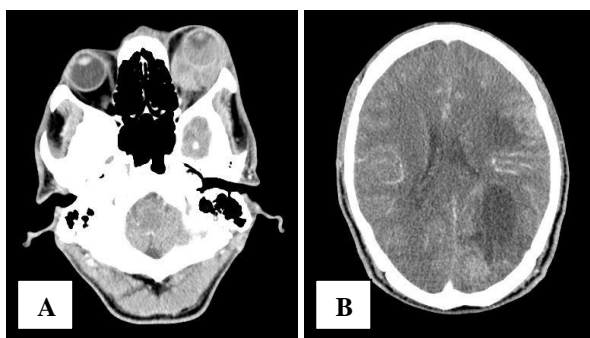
A. Orbital CT scan with contrast shows intraconal mass of retrobulbar oculi B. Head CT scan with contrast shows multiple mass in left occipital lobe, right and left parietal, and left temporal suspicious metastatic process.
